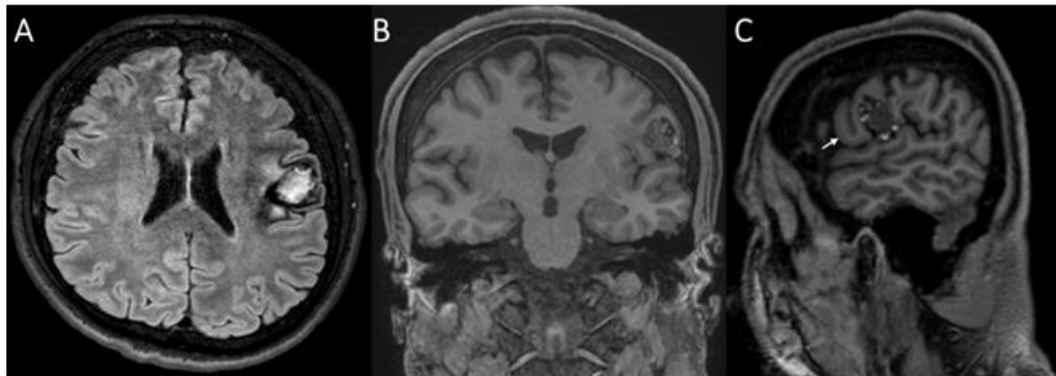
Preoperative MRI. A) FLAIR sequence showing a left paraopercular lesion with perilesional hypointensity B) and C) T1 without contrast with a lesion close to the left frontal pars opercularis (white arrow).
